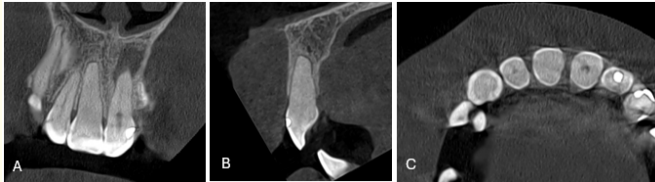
CBCT slices coronal (A), sagittal (B) and axial (C), showed no periradicular radiolucency, no resorption, and no fracture line; canal visibility was not evident.
